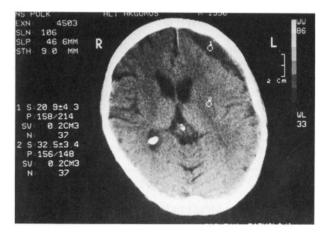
CT clearly demonstrates the suspicious association of positional lambdoid deformity of the skull and subdural hygroma.
